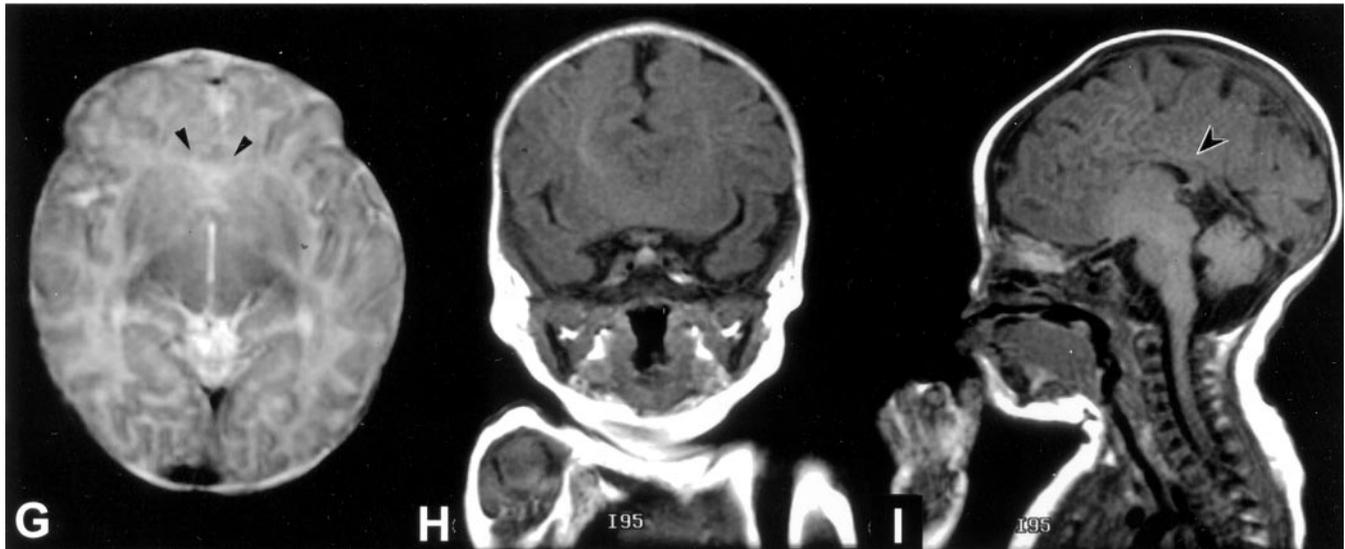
(A, B, and C) MRI of a patient with alobar holoprosencephaly (HPE). Axial T2-weighted image (A) demonstrates incomplete of separation of the two hemispheres, striatum, and thalami, and a large dorsal cyst (dc). Coronal T1-weighted image (B) shows a continuity of gray matter over the two hemispheres without an interhemispheric fissure. The ventricular system is composed of a single midline ventricle, monoventricle (mv). Sagittal T1-weighted image (C) shows absence of corpus callosum and a monoventricle that communicates freely with the dorsal cyst. (D, E, and F) MRI of two patients with semilobar HPE. Axial T2-weighted image (D) shows posterior portions of the hemispheres are well separated, but the anterior cerebral hemispheres are not cleaved. A dorsal cyst (dc) is present. The posterior horns of the lateral ventricles are well formed. The frontal horns are poorly developed (D) and posteriorly there is a monoventricle demonstrated on a coronal T2-weighted image (E, same patient as in D). A sagittal T1-weighted image of a different patient (F) demonstrates that the posterior portion of the corpus callosum is formed, but the anterior portion is not developed (arrowhead). This finding is highly characteristic of semilobar or lobar HPE. (G, H, and I) MRI of a patient with lobar HPE. Axial T2-weighted image (G) shows that the cerebral hemispheres are fairly well separated both anteriorly and posteriorly. There is some development of the frontal horns (arrowheads). Coronal T1-weighted images (H) shows failure of complete cleavage of the frontal lobe. A sagittal T1-weighted image (I) demonstrates that the posterior portion of the corpus callosum (arrowhead) is formed but the anterior portion is not developed.
